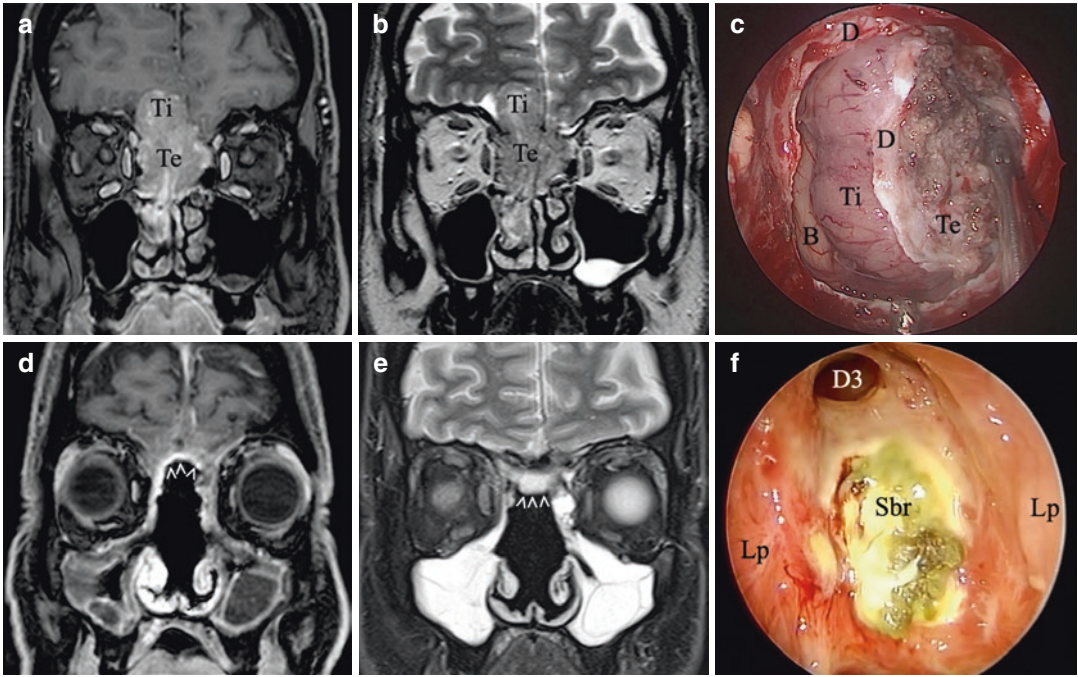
A 58-year-old male affected by right esthesioneuroblastoma Kadish C, Hyams II. The preoperative MRI scans in coronal views ((a) T1W with contrast; (b) T2W) and intraoperative view (c) show the intracranial extension of the disease. The patient underwent bilateral ERTC and skull base reconstruction with fascia lata followed by adjuvant radiotherapy (60/54 Gy on T/N). MRI
